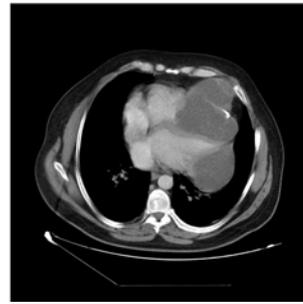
Dynamic Chest CT scan done 2008.
